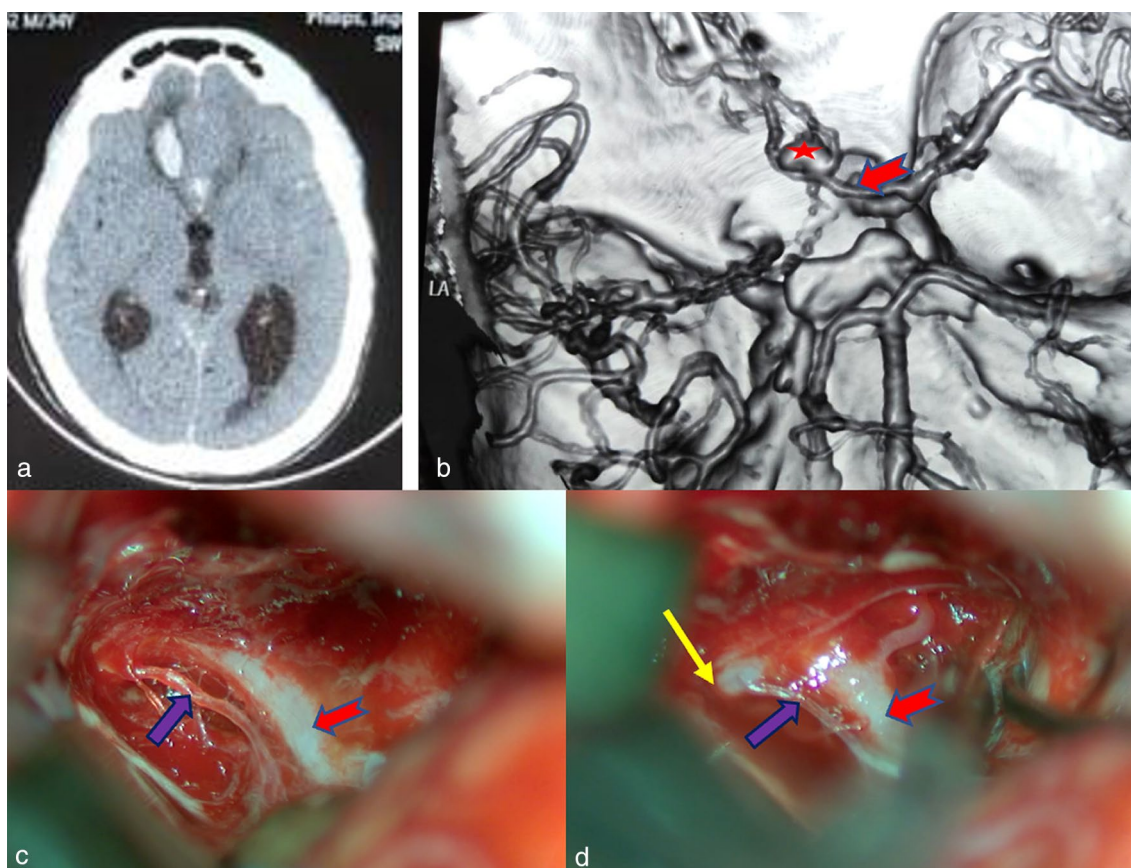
Plain CT scan head demonstrate hyper density (bleed) in the left gyrus rectus and adjacent basifrontal gyrus with subarachnoid hemorrhage in the interhemispheric fissure a. Reconstructed image of CT angiogram demonstrates a superiorly directed A- comm artery aneurysm (red star) with dominant right A1 b. Intraoperative images after right pterional craniotomy c and d demonstrates ipsilateral RAH (purple arrow) running parallel to the ipsilateral A1 (red arrow). After successful micro neurosurgical dissection, the ipsilateral A2 is identified and is well depicted in the image as the source of origin for RAH
